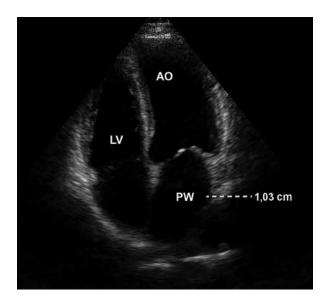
Transthoracic echocardiogram in parasternal long-axis
